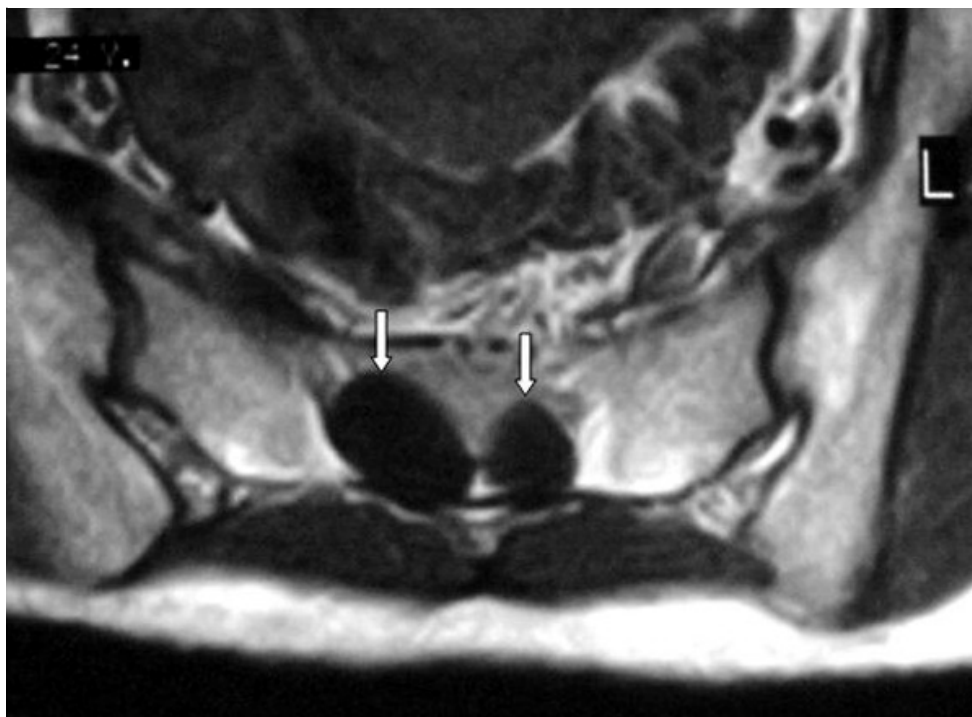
MRI of lumbosacral spine-An axial T1 weighted view shows two cystic lesions (arrows) in paramedian aspect of S2 spinal canal. The right cyst is larger than the left cyst
